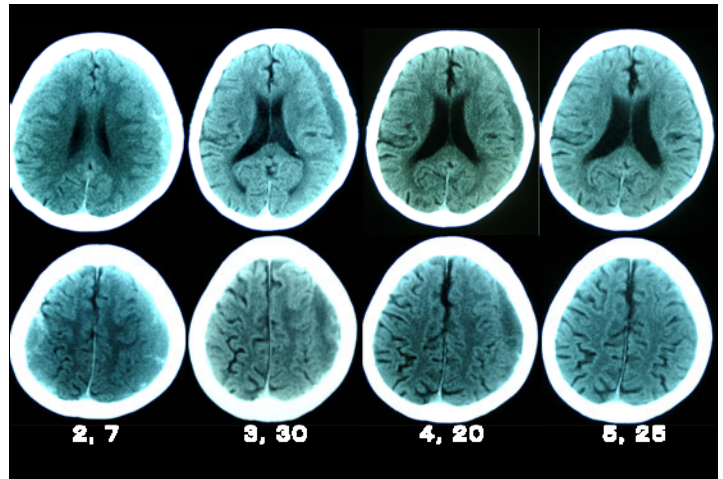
CT scan of case 2 (K.H.) before and after administration of *goreisan*. 06,2,7; before administration, 06,3,30; 06,4,20; and 06,5,25; 7, 10 and 14 weeks after administration of *goreisan*.
